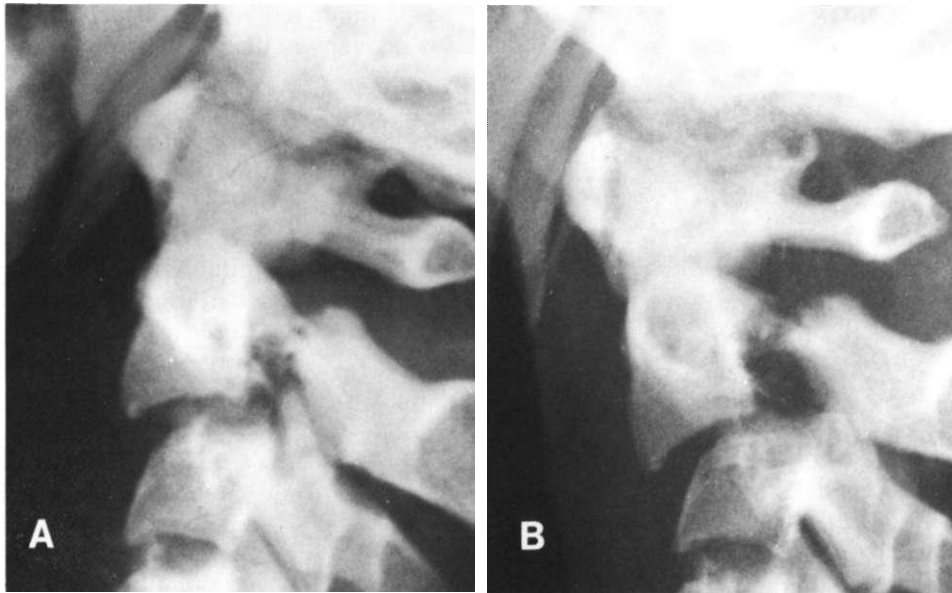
Radiographs of a young male who sustained a traumatic spondylolisthesis in an automobile accident. (A) Fracture dislocation without traction. (B) The instability of the lesion and the effect of 3 lb of axial traction. In this situation the annular and longitudinal ligament fibers between C2 and C3 were obviously destroyed in the injury. It is assumed that the MIV has a significant +y-axis component. In addition to the major y- and -x-axis torque, there is a tensile or shear load applied to the annulus. This does not always occur in such an injury. Note that the posterior elements of C2 had been pulled anteriorly, which was, no doubt, injurious to the cord. This patient died soon after admission to the hospital. (Courtesy of Teaching Library, Section of Neuroradiology, Yale University School of Medicine.)
